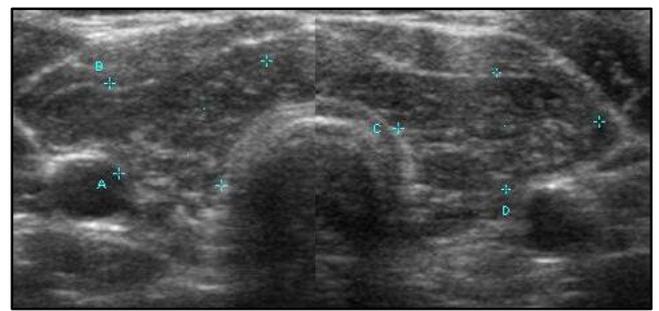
Ultrasound of a 36-year-old Female Showing Diffuse Enlargement, Hypoechoic Glandular Parenchyma, Coarse Echotexture and Fine Linear Strands Suggestive of Hashimoto's Thyroiditis.
